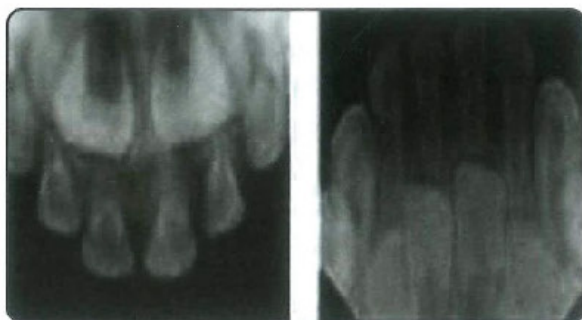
Occlusal x-ray of upper and lower anterior teeth
